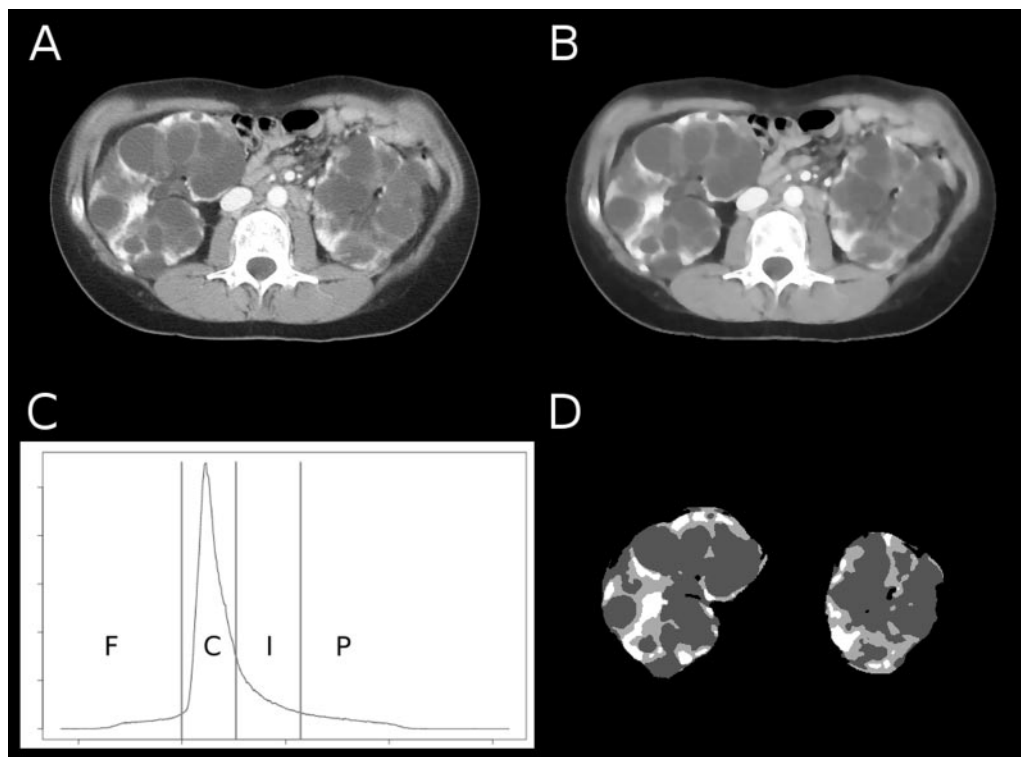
Representative computed tomography (CT) image before (A) and after (B) the application of anisotropic diffusion. (C) Image volume histogram and segmentation thresholds (F, fat; C, cysts; I, intermediate; P, parenchyma). (D) Segmented kidney tissue components.
